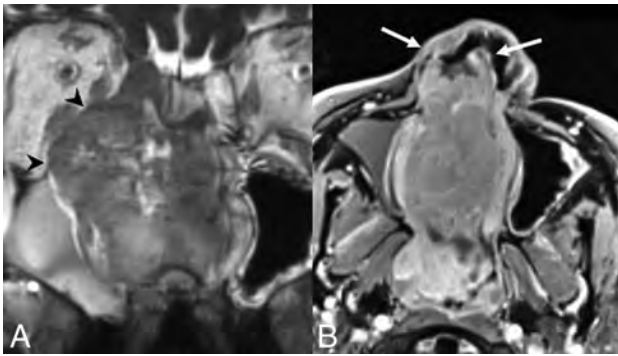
HPV-related sinonasal carcinoma, a nonmultiphenotypic variant. Coronal T2 (A) and axial T1 postcontrast, fat-saturated (B) MR images show a right nasoethmoid mass with extension to the right maxillary sinus and orbit (*black arrowheads*) as well as the left nasal cavity. There is anterior extension into the right nasal vestibule (*white arrows*). The mass demonstrates heterogeneous hyperintensity relative to the cortex on T2WI and avidly enhances. Images are courtesy of Dr Nafi Aygun, Johns Hopkins Hospital.
